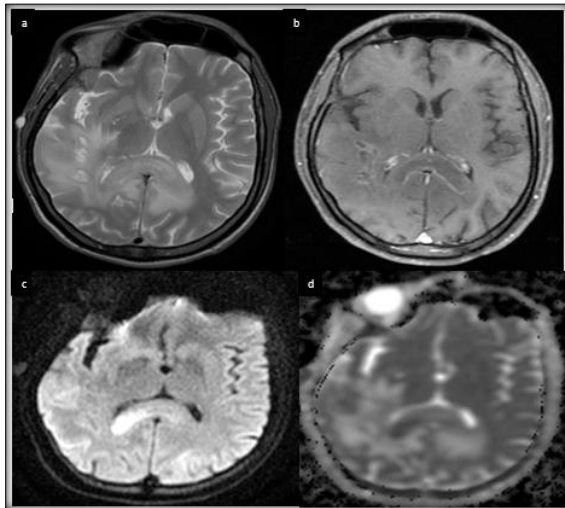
(a) T2 axial image shows heterogeneously hyperintense lesion in right occipital region with perilesional oedema, extending to the splenium of corpus callosum crossing midline. (b) T1 axial post contrast image shows peripheral enhancement of the lesion. (c) DWI and (d) corresponding ADC images show diffusion restriction with low ADC values. These features are likely suggestive of CNS lymphoma. Origin: Department of Radiology , Jorhat Medical College and Hospital, Jorhat , Assam , India 2025
